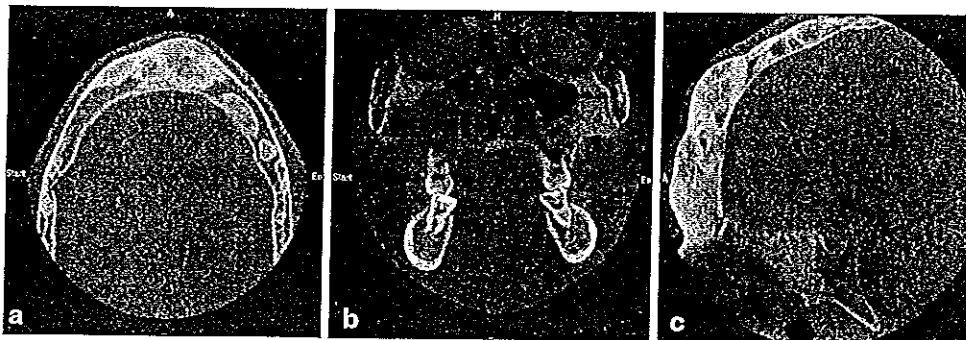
a Axial, b coronal, and c sagittal CBCT images showing numerous radiopaque lesions that involve craniofacial structures such as the cranial vault, maxillary bone, zygoma, paranasal sinuses, sella turcica, and jaws
